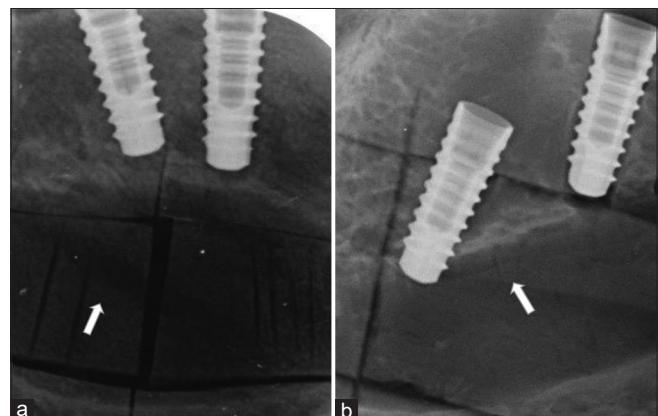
(a) Periapical radiographs of control implants, and (b) periapical radiographs of implants with pilot drill injury to the inferior alveolar nerve canal (right implant) and penetration of the inferior alveolar nerve canal (left implant). Arrows point to inferior alveolar nerve canal.
